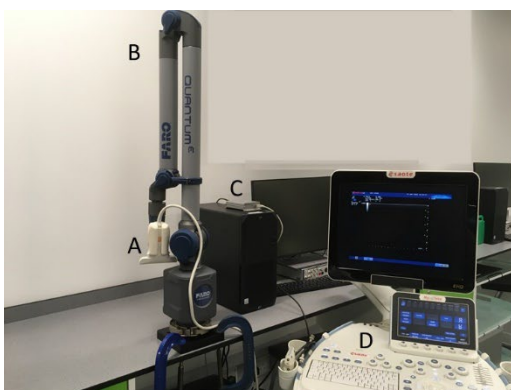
A) Custom designed probe holder, with probe. B) Quantum^s. C) Frame grabber, connected to computer and ultrasound scanner. D) Ultrasound scanner. Right panel: 360 view of the custom made probe holder.
